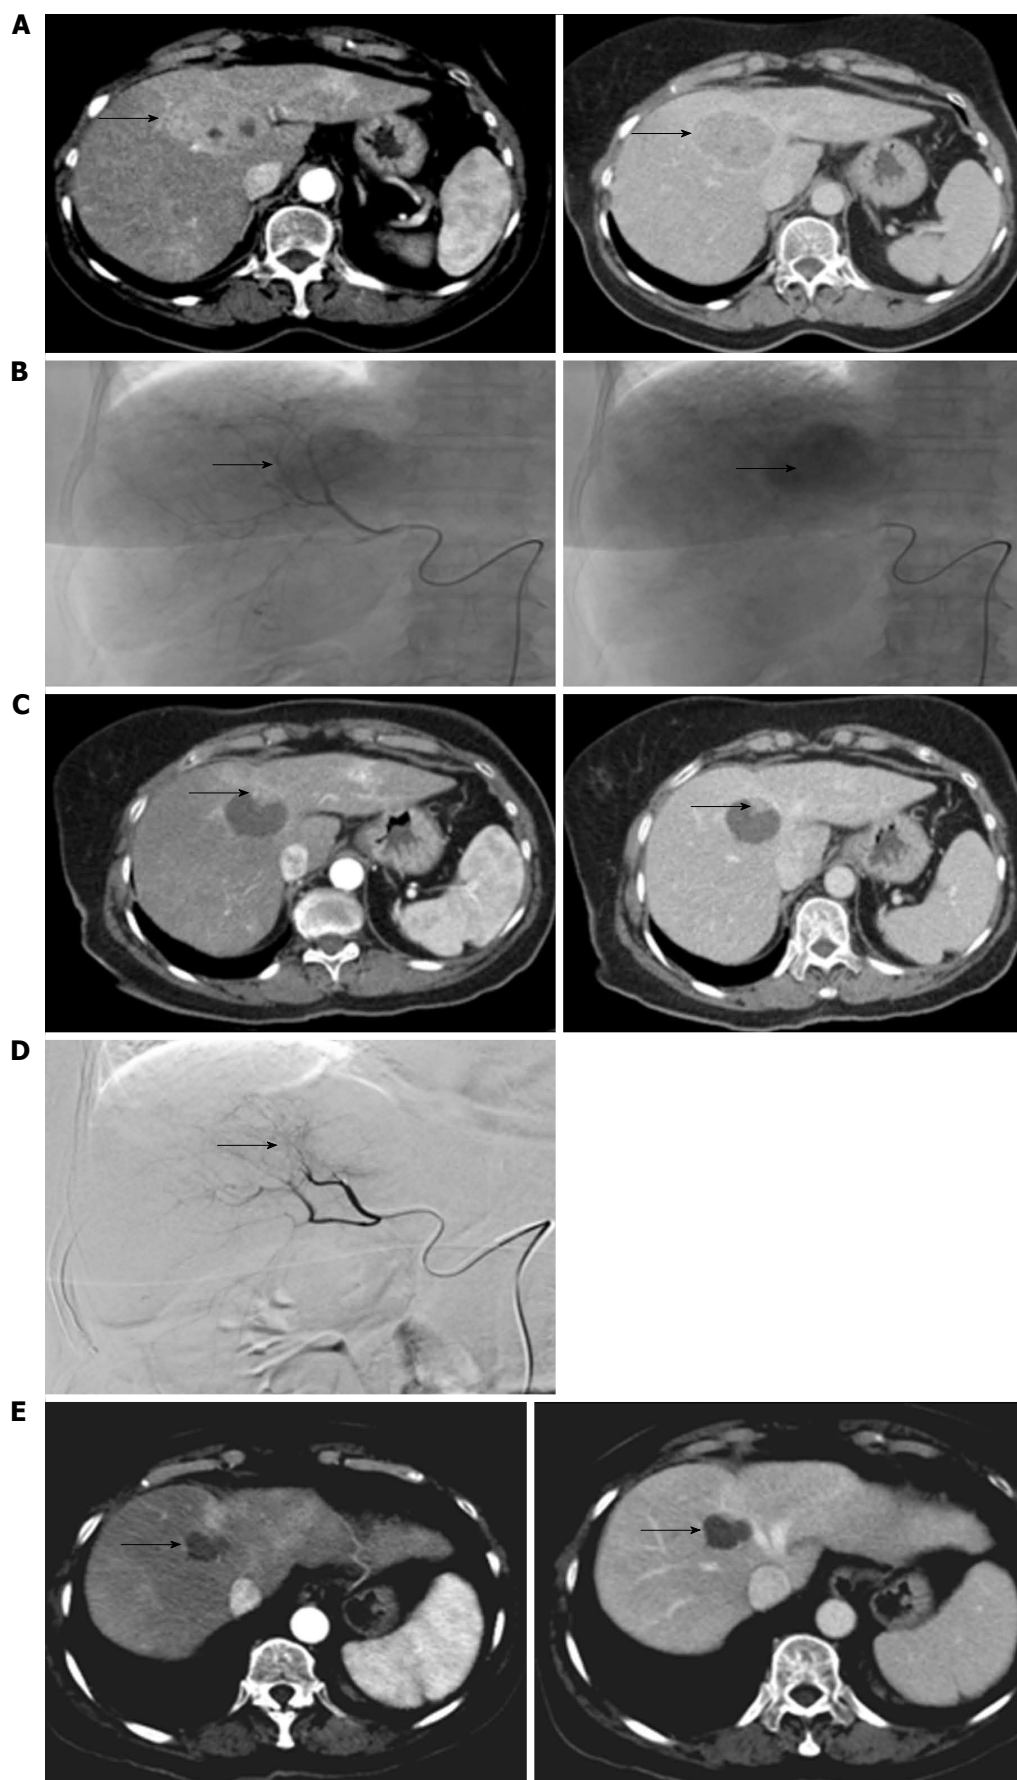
Transarterial chemoembolization for hepatocellular carcinoma. A: Four centimeter hepatocellular carcinoma S-IV. Arterial and venous phase computed tomography; B: First transarterial chemoembolization procedure; C: Small residual foci after 1 transarterial chemoembolization; D: Second transarterial chemoembolization; E: Complete response after 2 transarterial chemoembolization.
